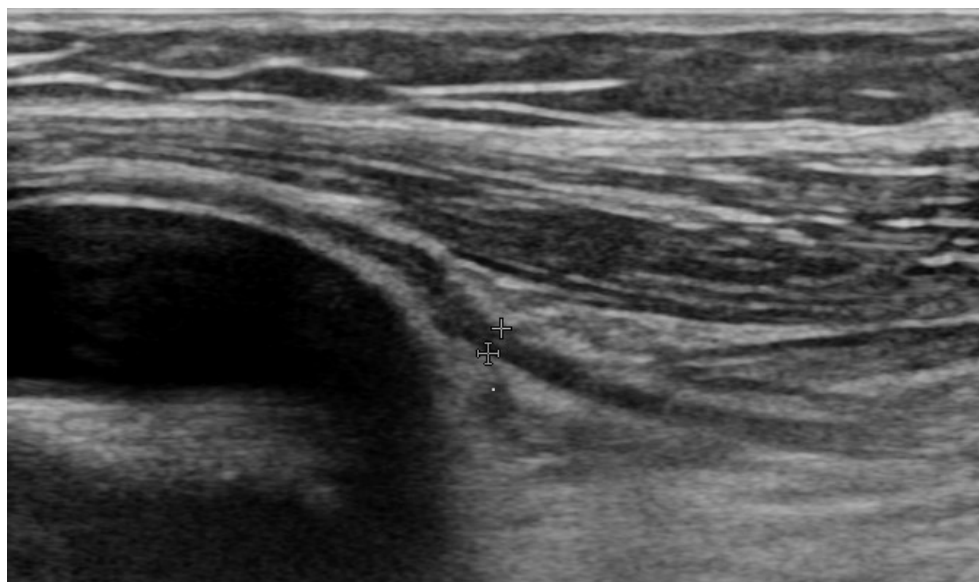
High resolution ultrasound image showing common peroneal nerve (arrowheads) lying stretched over the underlying cystic lesion
